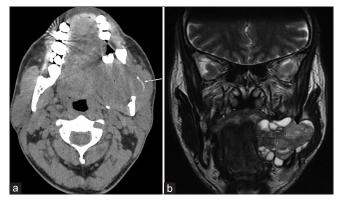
(a) Mixed solid-cystic lesion (5 cm transverse x 4.5 cm superoinferior) with well-defined margins seen in left mandible in coronal T2- weighted MRI image; (b) Lingual (inner) cortex is destroyed & part of buccal (outer) cortex is thinned (arrow) in axial CT image (soft tissue window) of expansile lytic lesion (4 cm anteroposterior) in left mandible.
